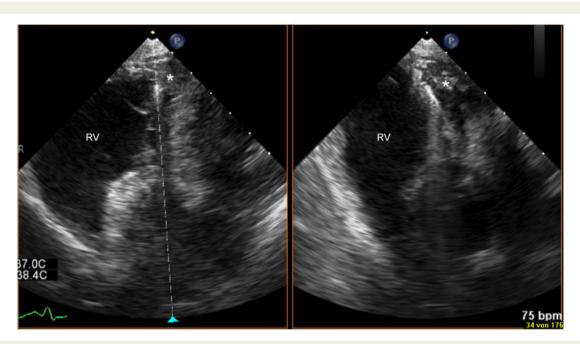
Transoesophageal echocardiography. Guiding of endomyocardial biopsy in two planes. RV, right ventricle. \*Intracardiac mass.
